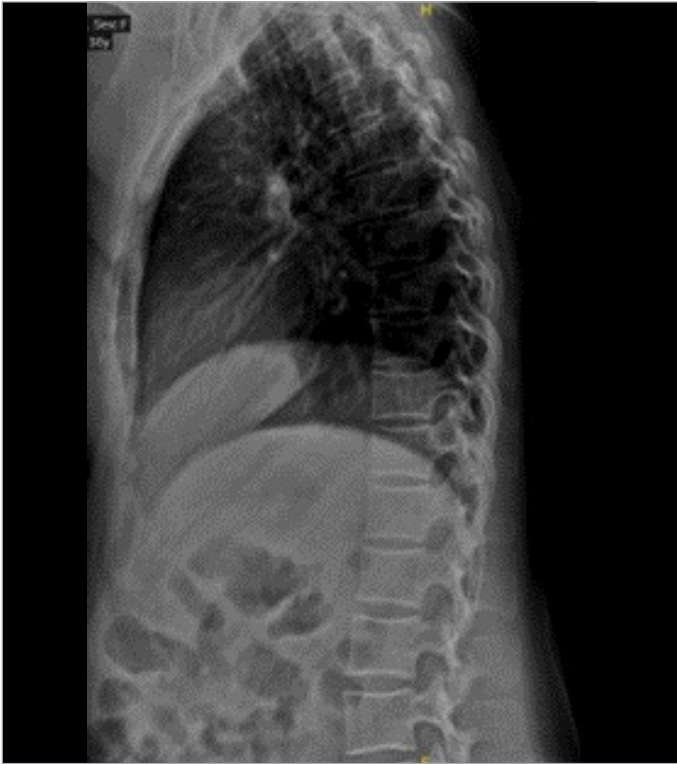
Radiographic examination of the spine
